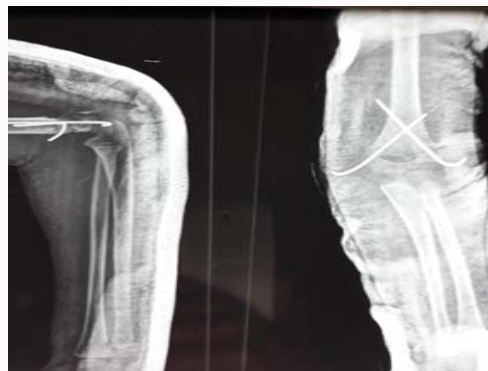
Immediate post-operative radiography.
